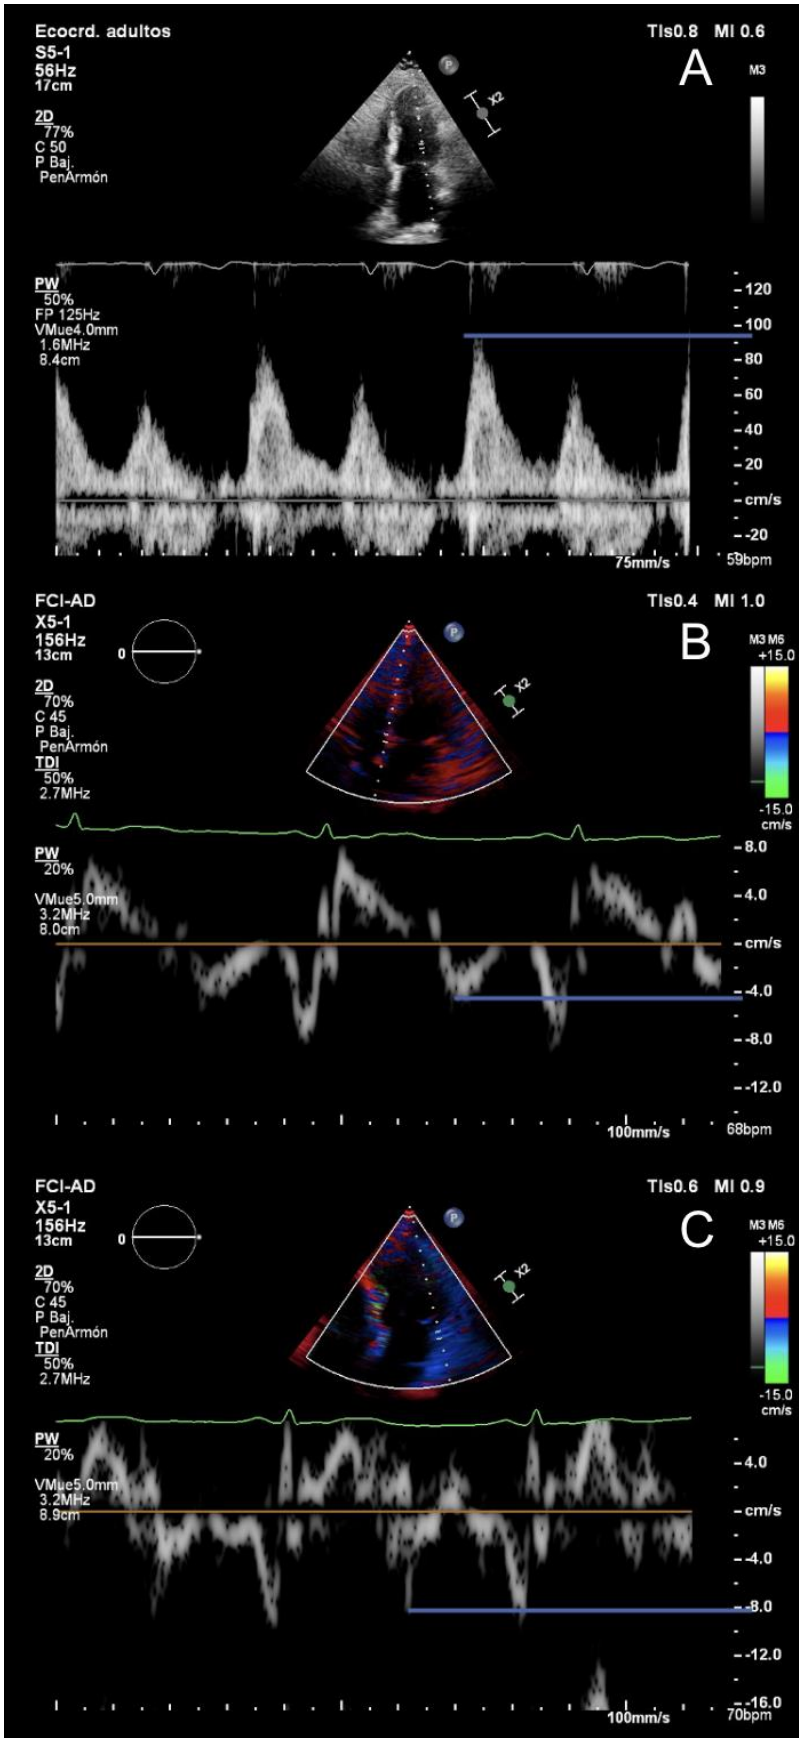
Diastolic function assessment on 2-Dimensional Transthoracic Echocardiogram
